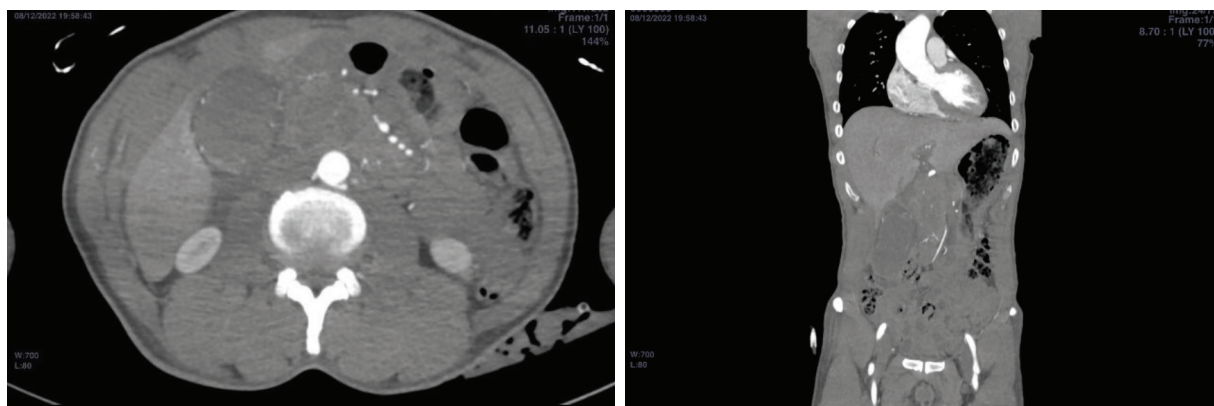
Axial CT abdomen initially
